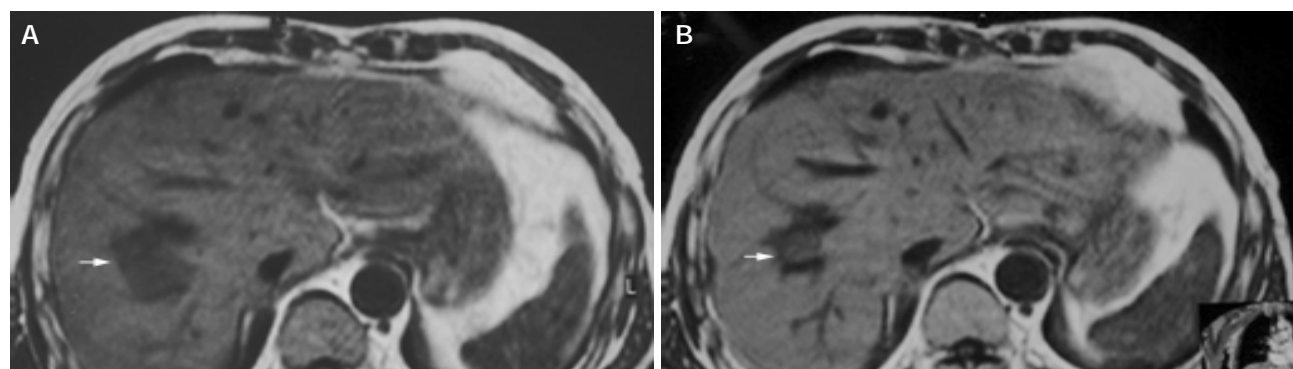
A 55-year-old man with metastatic hepatocarcinoma in sigmoid cancer postoperation. A: MRI images before HIFU treatment showed that liver tumor of right-posterior lobe was 40 mm×30 mm×30 mm; B: MRI images 2 wk after HIFU revealed that liver tumor of right-posterior lobe obviously decreased in size (20 mm×20 mm×15 mm).
